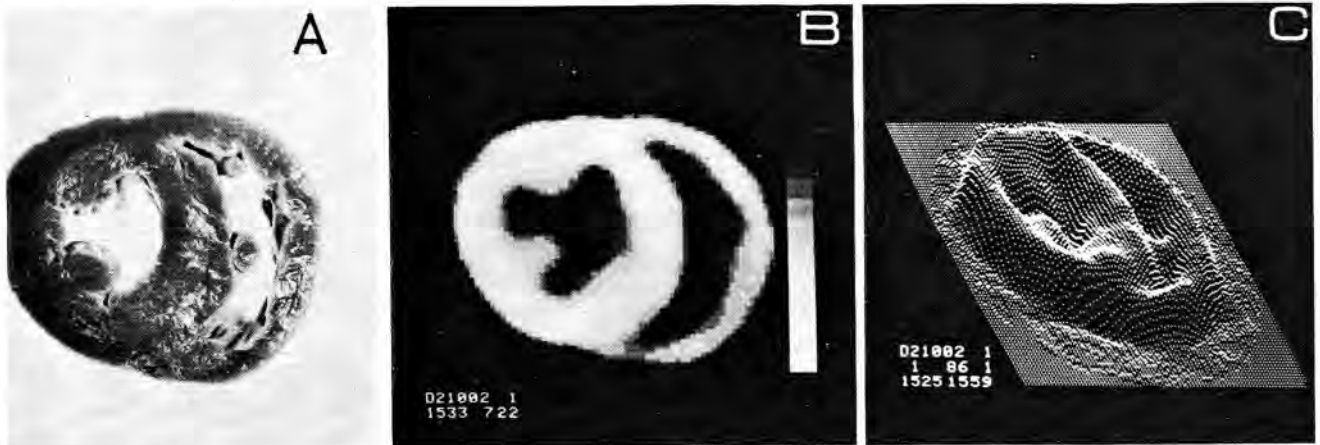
A, Cross section of a postmortem heart. B, Cross section reconstructed with ultrasound-velocity tomography in the plane of A. C, Plot of ultrasound velocities (plotted vertically) in the plane of measurement.
